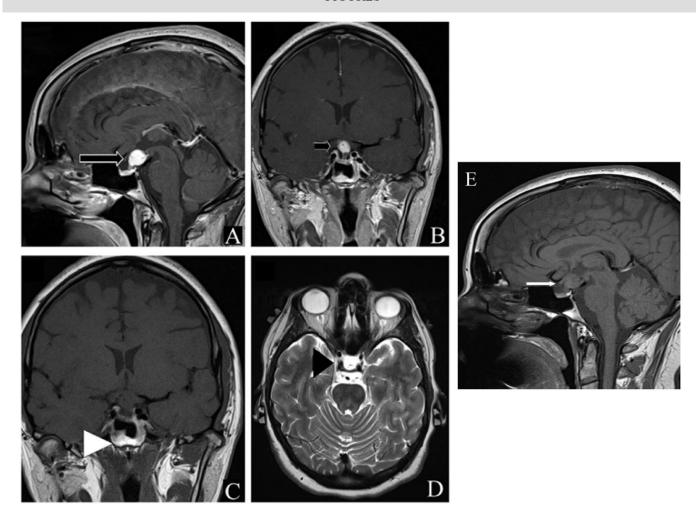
38-year-old female with sporadic hemangioblastoma of infundibulum. Technique: Gadolinium enhanced 3T MRI of the brain, pituitary protocol. Sagittal and coronal post-contrast T1 weighted images and axial T2 weighted image through the pituitary fossa.
